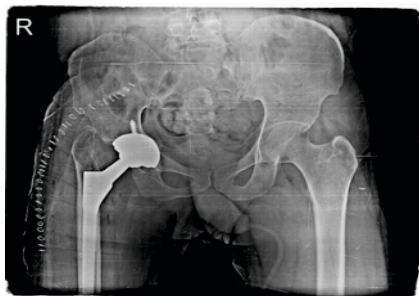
Here is the immediate post operative Xray of this patient.
